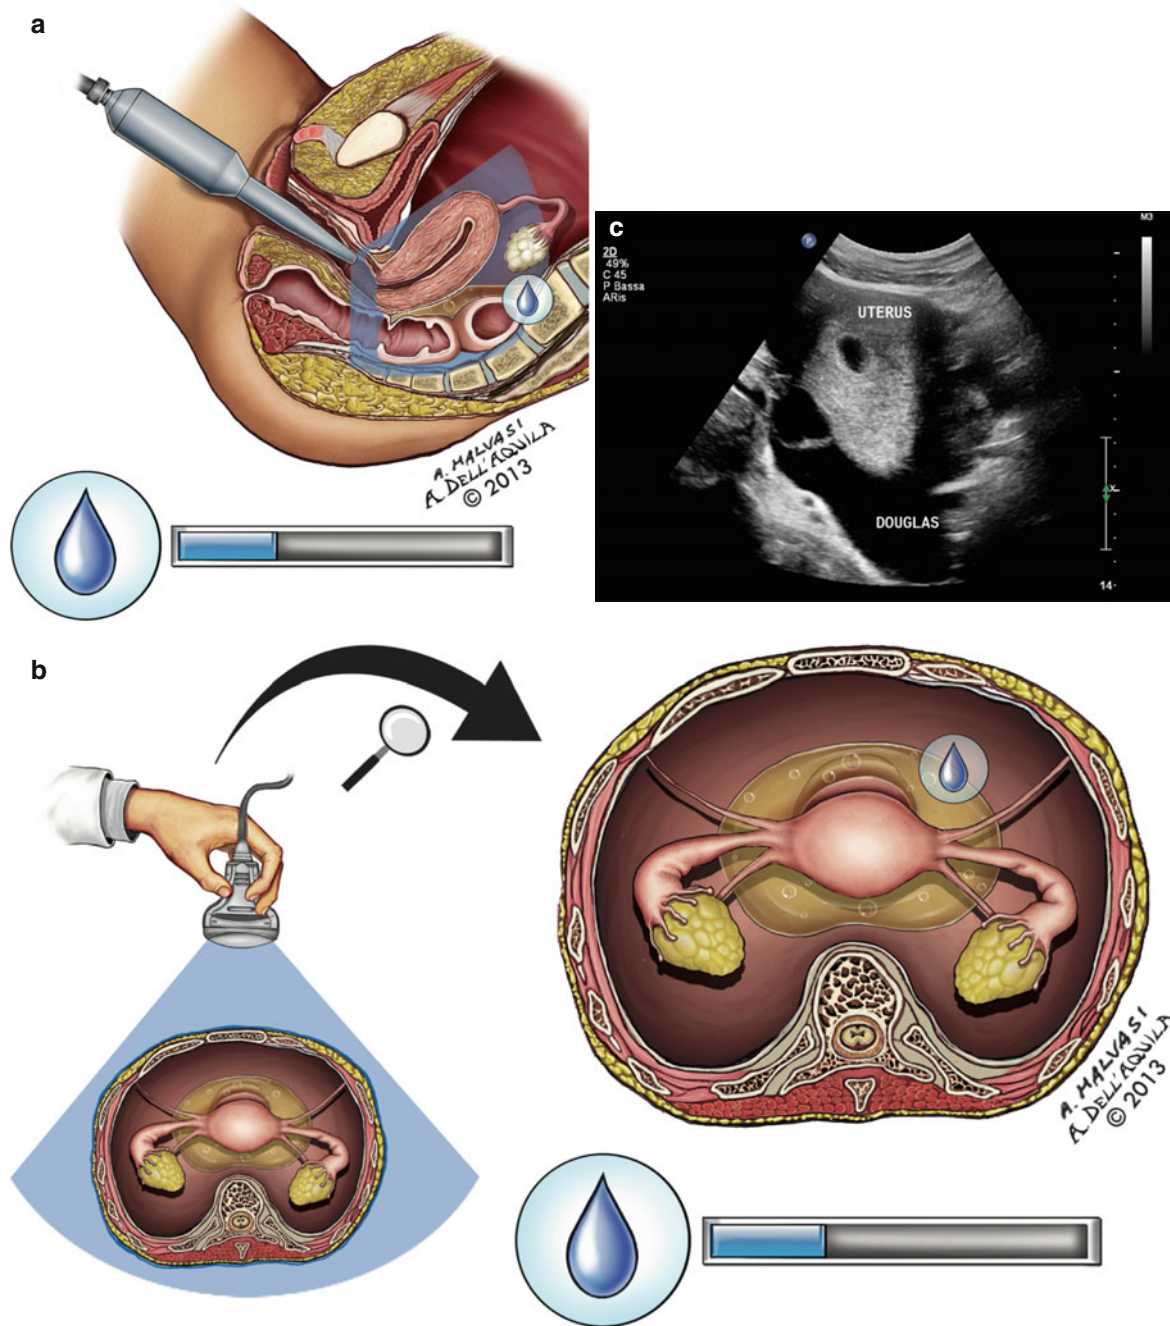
(a, b) The mild ovarian hyperstimulation syndrome (OHSS) is represented, on the *left*, by a transvaginal ultrasonographic (US) scan and, in the *middle*, a transabdominal (US) examination, on the *right* an ultrasonographic photo
